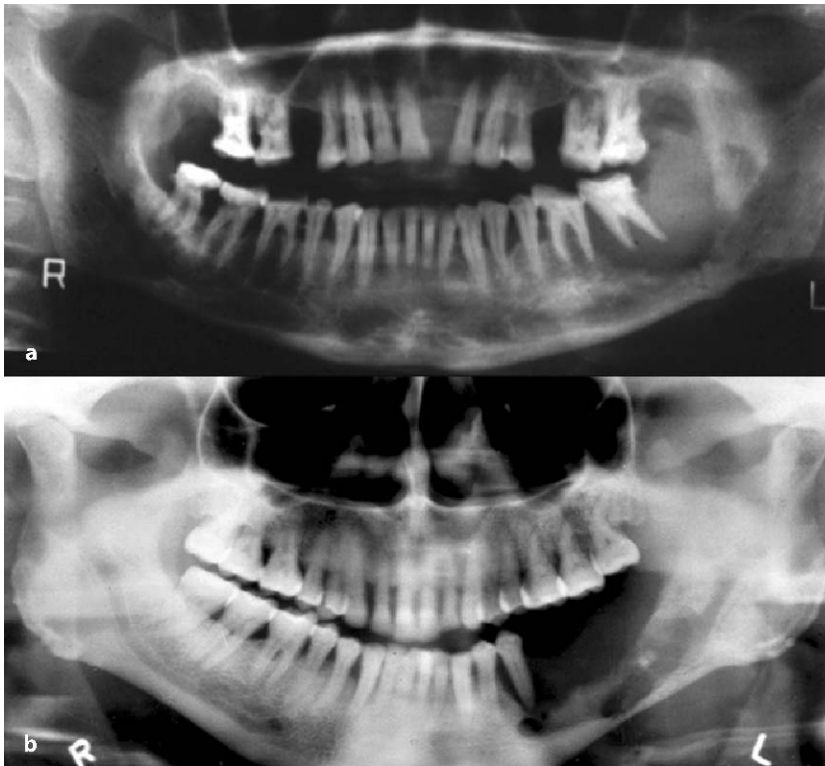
a, b Panoramic radiographs from patients having advanced oral cancer with secondary invasion of the mandible. Note the “saucerization” of the upper surface of the left side of the mandible in both of these cases. Both cases also show “floating teeth” where supporting bone has been destroyed. Case (b) shows invasion of the mandibular canal
